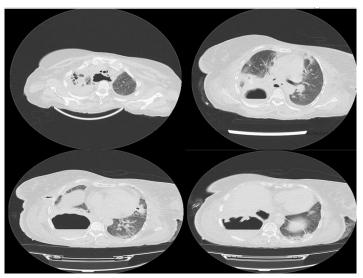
A chest CT of the patient showed pneumomediastinum in the upper part of the mediastinum, loculated pleural effusion with several foci of air in the upper part of the right lung, severe hydrothorax and pneumothorax in the right lower lobe (RLL), and evidence of consolidation in the lower part of the left lung in the context of aspiration pneumonia.
